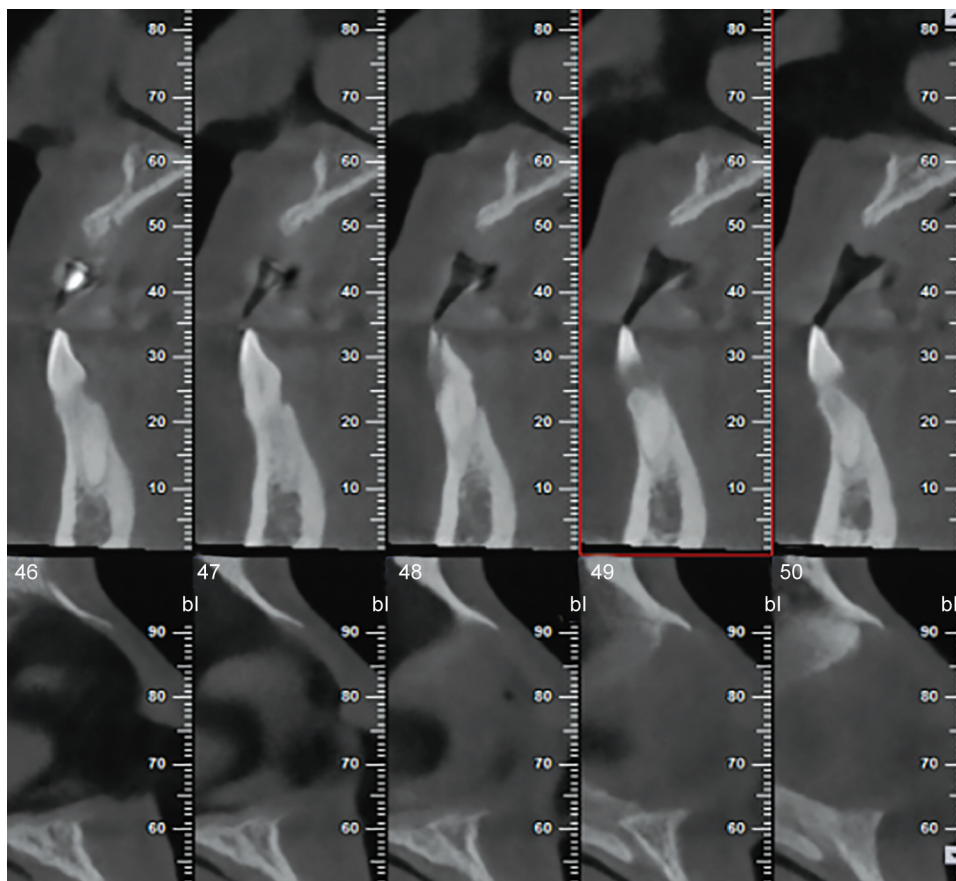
Sagittal view CBCT at the time of initial presentation
